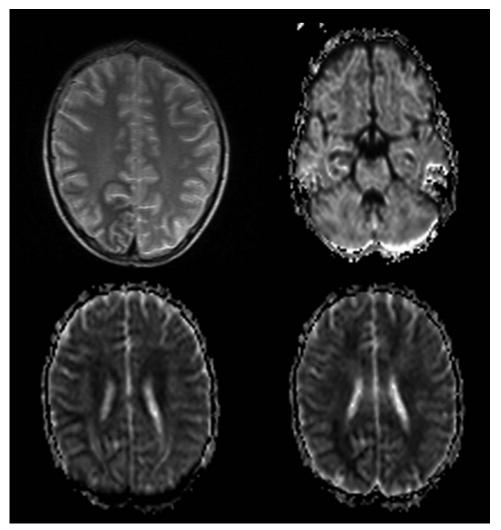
The MRI of the patient at admission showing multiple areas with a signal change in the temporal (right upper), occipital (left upper), and medial of right parietal (right and left inferior) accompanied with diffuse cerebral atrophy.
